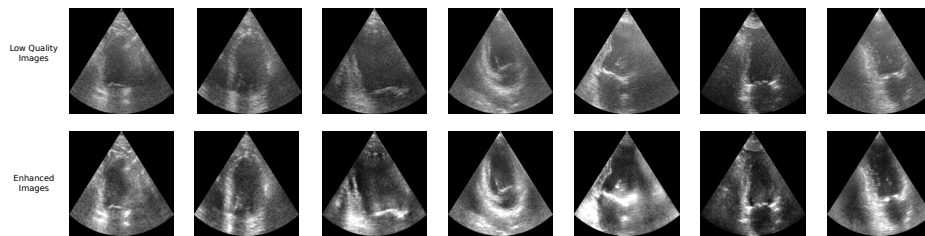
Qualitative comparison of the low-quality and enhanced images using UltraGAN. Our method is able to enhance ultrasound images, improving the interpretability of the heart structures regardless of the view.
